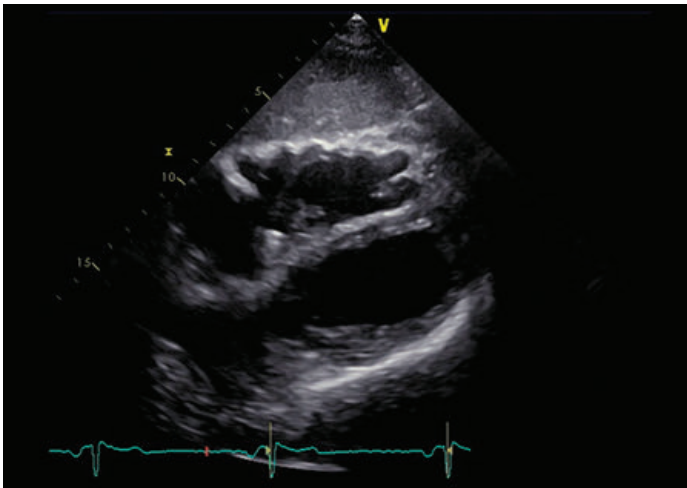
3 Echocardiographic image (subcostal view) of the right ventricle from a patient with ARVC/D diagnosed according to the revised Task Force Criteria.⁴ The right ventricle is dilated, and several aneurysms are detectable in the midventricular and apical inferolateral wall.
